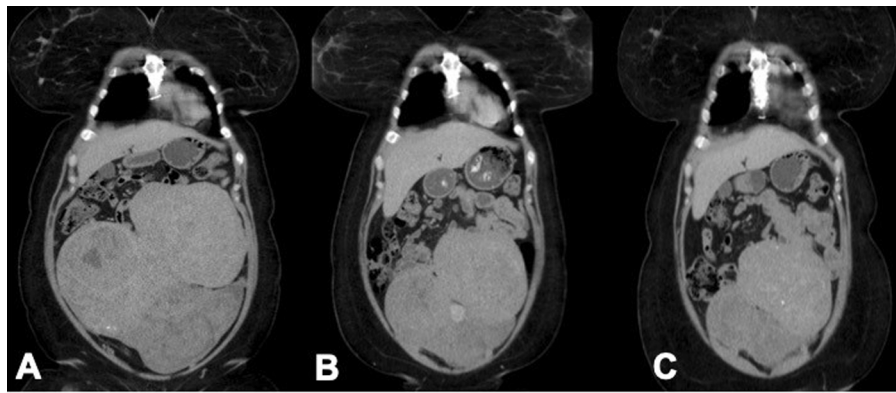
Coronal CT reformat from a contrast enhanced CT performed in July 2010 (A), September 2010 (B) and 2012 (C) shows shrinkage of the masses.
